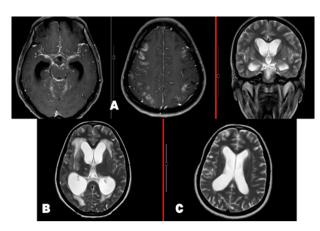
30 years immunocompetent lady presenting with fever, headache of 3 weeks duration with increasing drowsiness of 1 week duration along weight loss and other constitutional features. MRI head showing A and B: Tiny nodular enhancing lesions in bilateral basal ganglia- thalamic location, brainstem and cerebellum along with diffuse leptomeningeal enhancement overlying bilateral cerebral hemispheres & basal cisterns and resultant ooze decompensated extraventricular obstructive hydrocephalus- suggesting Tubercular meningitis. Imaging done 2 months after initiation of ATT(B) still revealed basal exudates along with hydrocephalus & periventricular ooze which improved on subsequent follow up (C)
